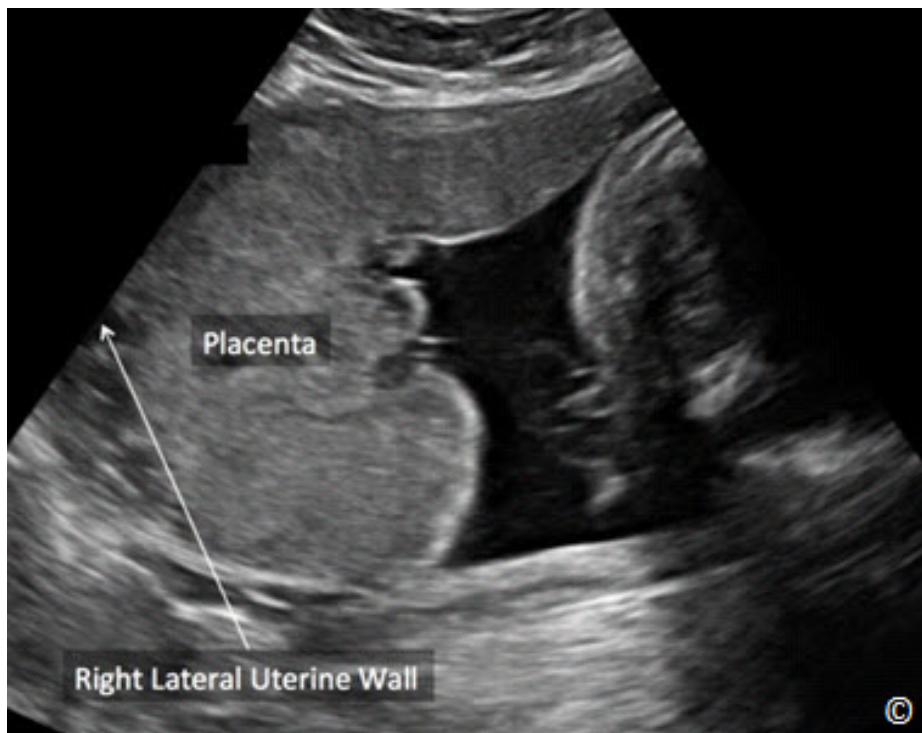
Right lateral placenta (labeled) shown on ultrasound obtained from a sagittal view of the uterus. Right lateral uterine wall is labeled. See text for details.
